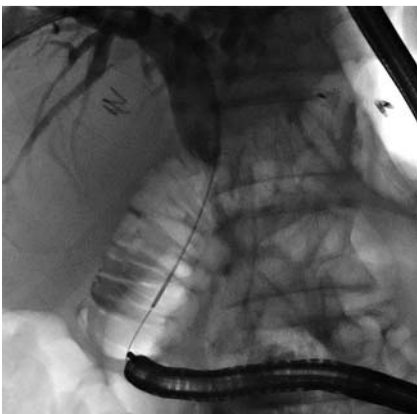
Abdominal radiograph showing the guidewire being grabbed using the endoscope.
